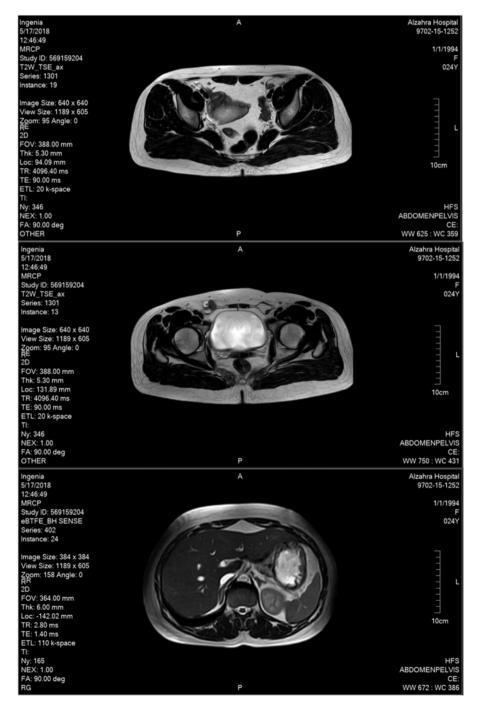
Magnetic resonance imaging (MRI) slides represent of the area being examined. The name and surname of the patient have been removed from the slides according to the ethical principles.
